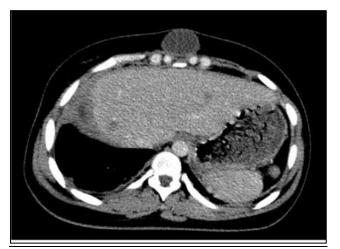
Abdominal CT scanAppearance in favor of sternal osteitis withcollection of opposite mole
